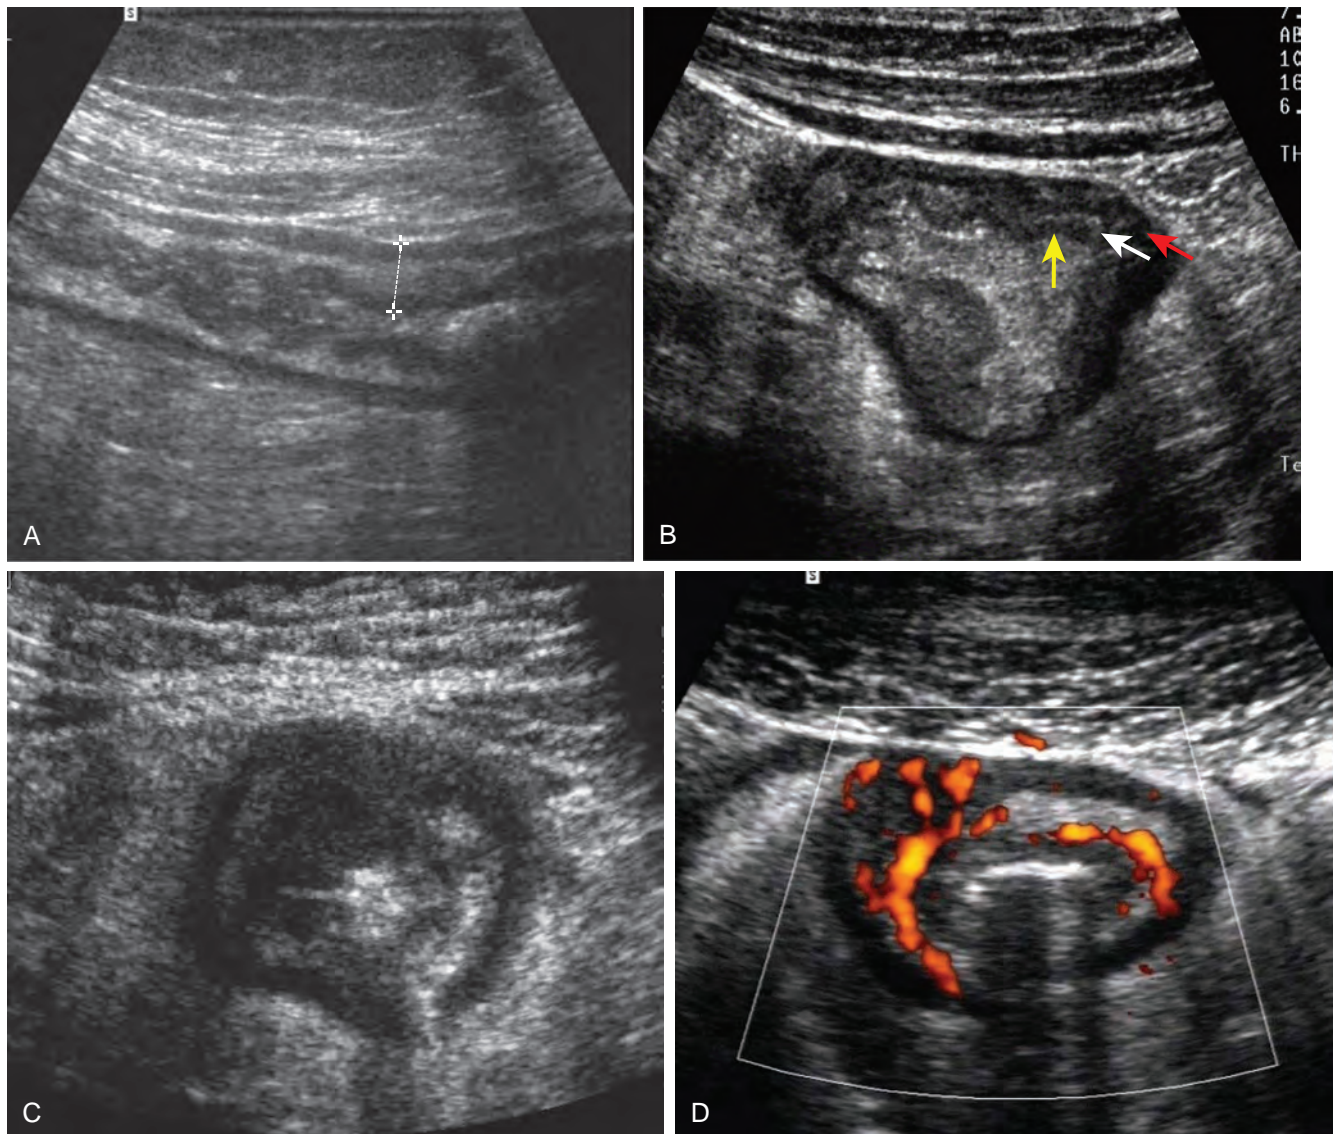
Crohn's disease: Sonographic features. A. Mural thickening is the sonographic hallmark of Crohn's disease. B. In acute disease, mural stratification is maintained. Yellow arrow, mucosa-muscularis mucosae; white arrow, submucosa; red arrow, muscularis mucosae. C. In chronic Crohn's disease, mural stratification is lost. D. The density of vessels seen on color flow Doppler ultrasound correlates with the degree of disease activity. (Courtesy Dr. Pierre-Jean Valette, Lyons, France.)
